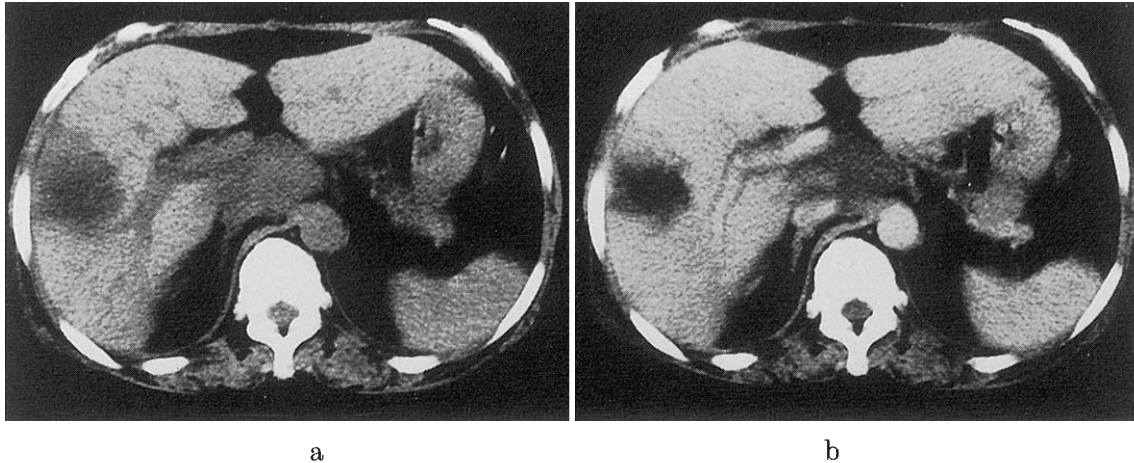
Abdominal CT scans obtained on July 5, 1994. (a) Unenhanced CT scan demonstrated a low density area in the right hepatic lobe, which was bigger than that of June 23, 1994. (b) Enhanced CT scan demonstrated that the margin of the low density area of the liver was enhanced, suggestive of a liver abscess.
